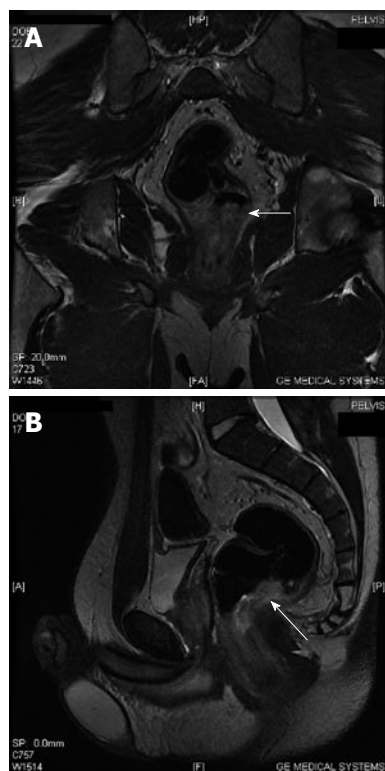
Coronal (A) and sagittal (B) T2 sequence MRI demonstrating the polyp (arrows).
